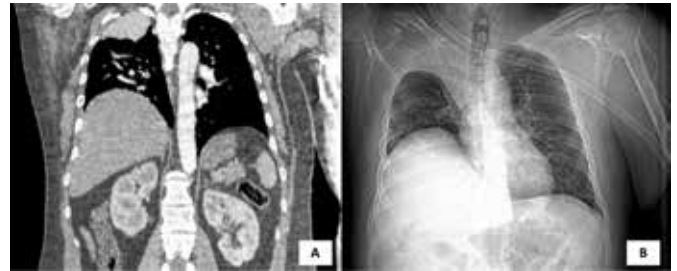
Images of the patient. A. CT angiography of the chest showing elevation of the right diaphragmatic dome and almost complete atelectasis of the upper lobe of the right lung. B. Chest X-ray showing the same CT findings
